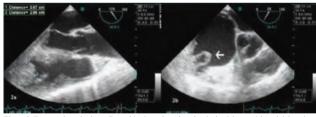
Transesophageal echocardiographic views show thrombus in the right ventricle and right atrium
